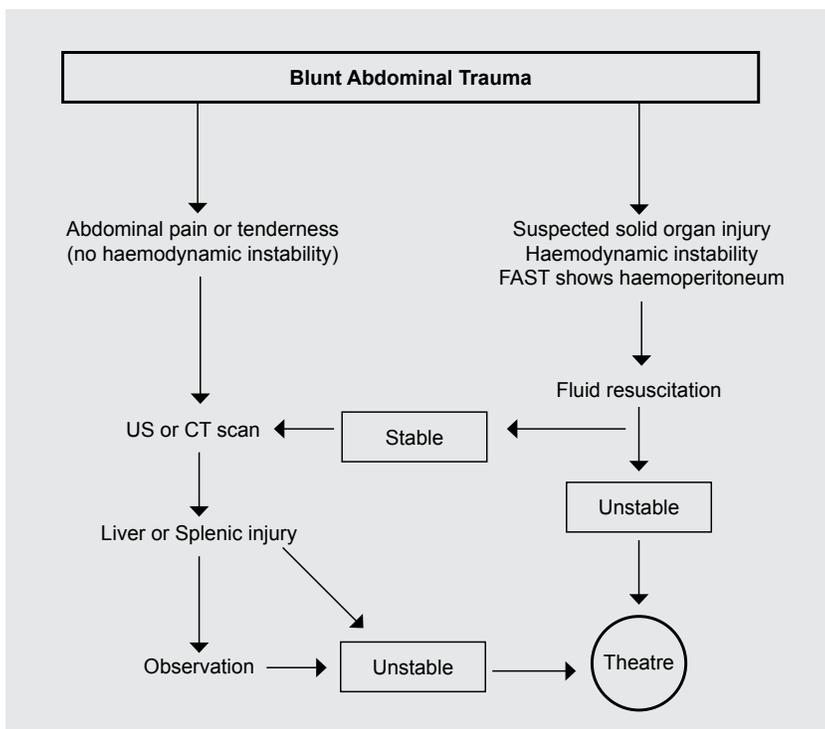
Algorithm for the management of blunt splenic or liver injury when CT or US is available. FAST is used for the rapid detection of haemoperitoneum in unstable patients, whereas detailed US may be used for the evaluation of stable patients.
